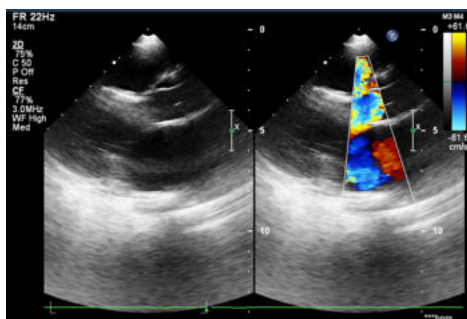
Parasternal long axis view shows perimembranous VSD
